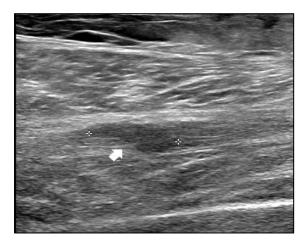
Ultrasound of calf area showing lobulated hypoechoic mass of the tibial nerve.
